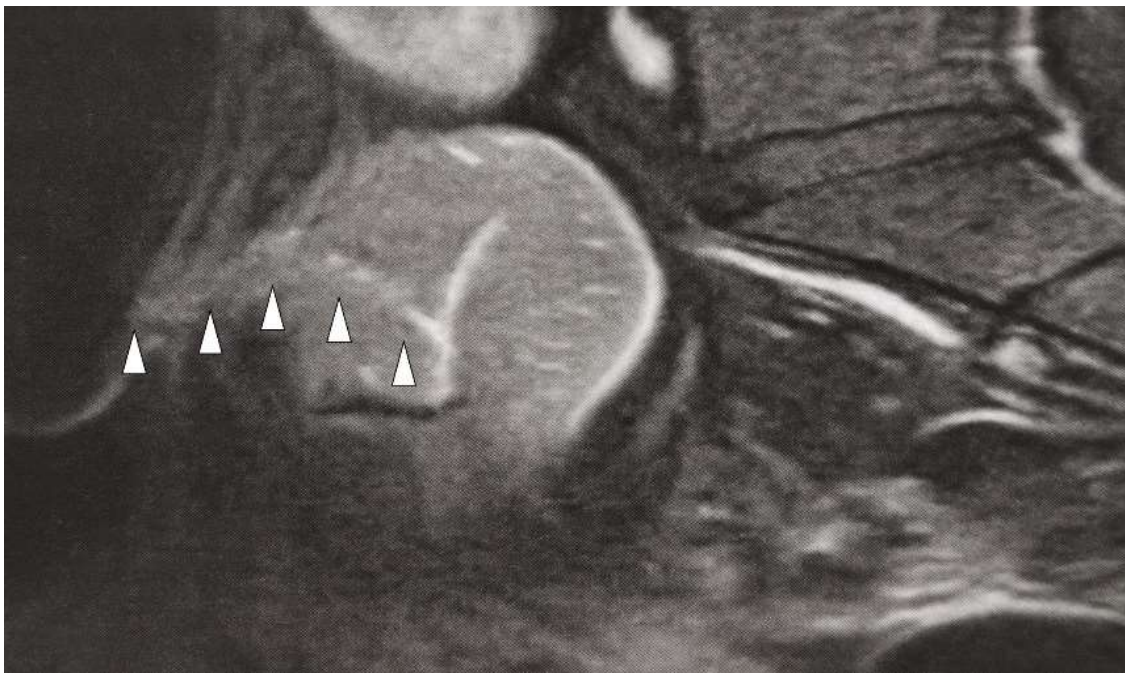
Pelvic MRI : Sagittal T2-weighted demonstrates a linear, fluid-signal (T2-hyperintense) fistulous tract (arrowheads) originating from the anterior lower uterine segment at the cesarean-scar region and extending anteriorly through the uterovesical/anterior peritoneal interface and preperitoneal soft tissues toward the anterior abdominal wall, consistent with a uterocutaneous fistula.
